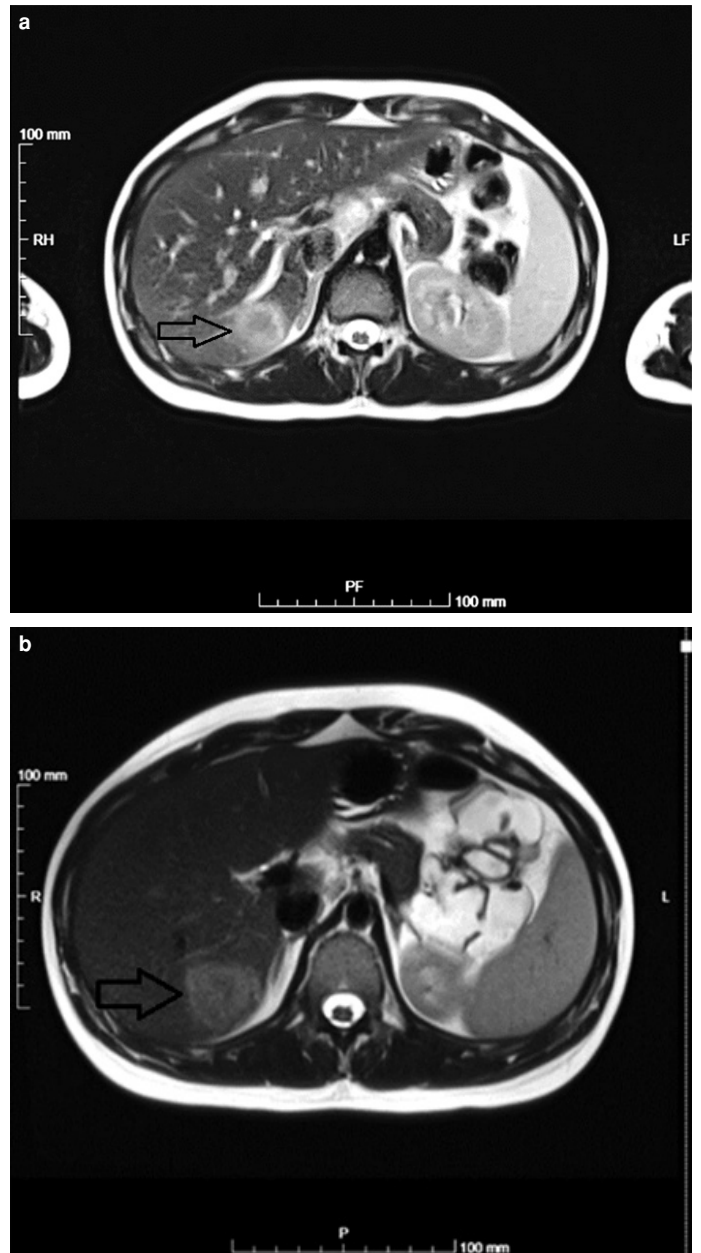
(a) Abdominal MRI T2 showing a mass hypointense in the center and hyperintense in the periphery at segment VI of the liver. (b) Dynamic contrast MRI enterography showing the progression of this lesion 3 months after the first abdominal MRI (see arrow).
